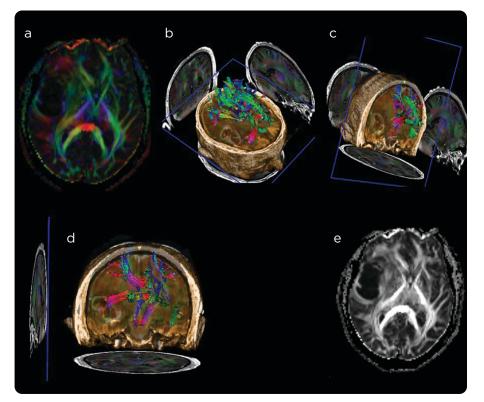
MRI of the brain with tractography. a) In cross section, b) transverse volumetric reconstructions, and c and d) coronal, e) tractography source image.
